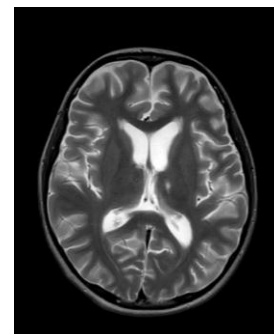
1. MRI brain (Axial T2 W image) showing small hyperintense signal in left thalamus
